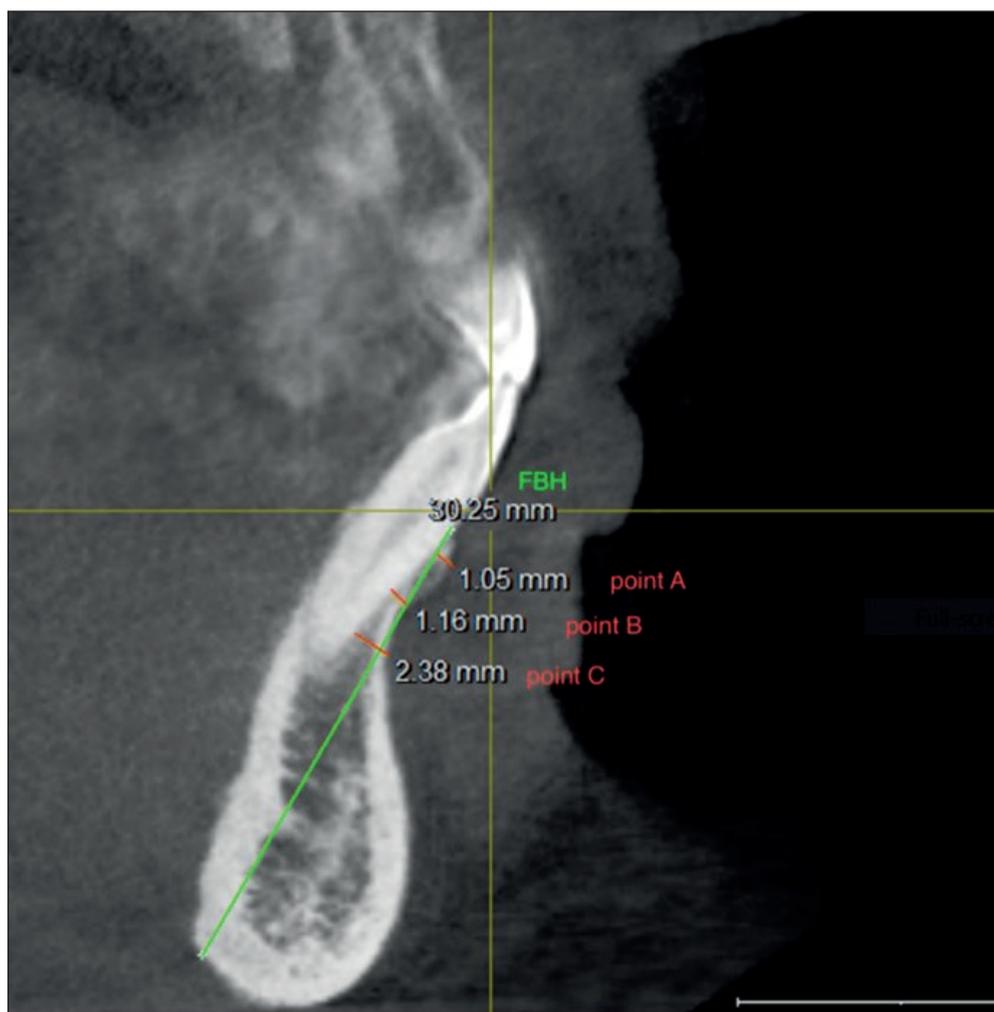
Measurements of the facial plate of bone thickness in an axial view from the facial aspect of the tooth root in the CBCT. Point A, Thickness measurement from the facial plate at the level of the bone crest to the coronal root third. Point B, Thickness measurement from the facial plate to the mid root surface. Point C, Thickness measurement from the facial plate to the apical root third. (FBH) Facial bone height was measured as the distance between the alveolar bone crest and the lowest point on the mandible's border along the root's long axis (Green line).
